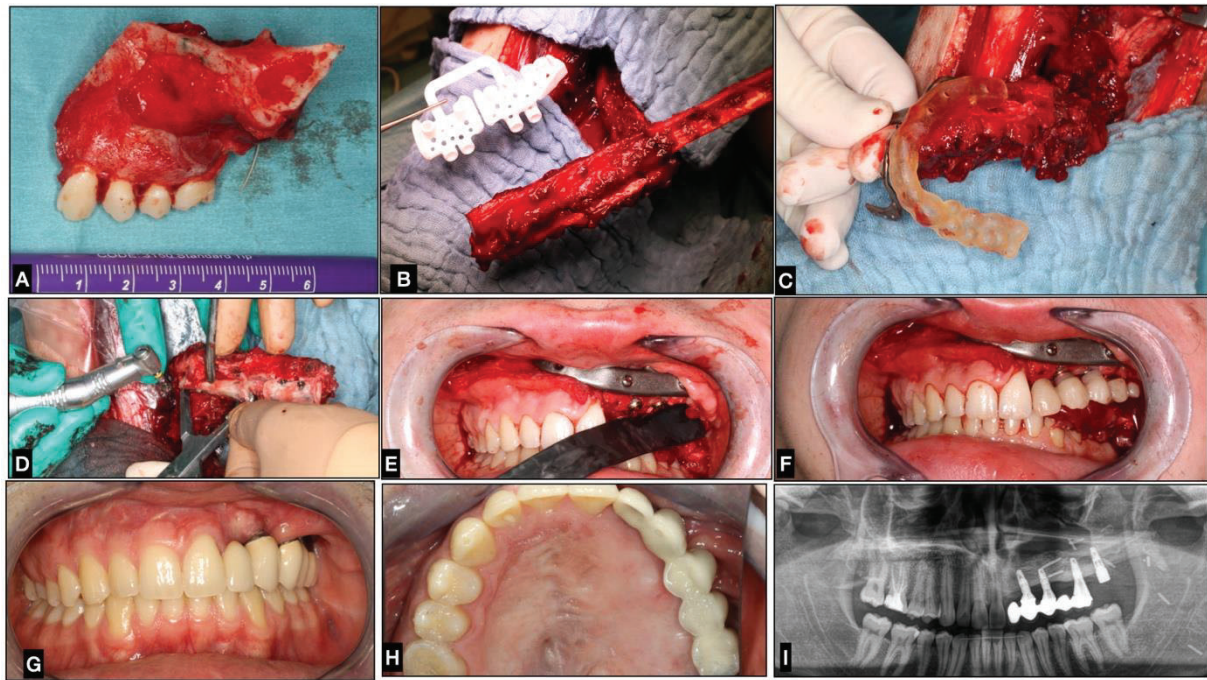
"Jaw in a Day" surgical procedures: A) maxillary resection of keratocystic odontogenic tumor; B) fibula raising and the cutting guide; C–D) implant insertion with guiding splint; E) fibula flap fixation to the maxilla; F) insertion of the temporary bridge with moderate aesthetic results; G–H) after insertion of the final bridge; I) panoramic x-ray after prosthetic treatment. The implant in the second molar region could not be included in the prosthetic treatment and remained a sleeping implant. Clinical case of the Department of Oral and Maxillofacial Surgery, University Hospital Giessen.
